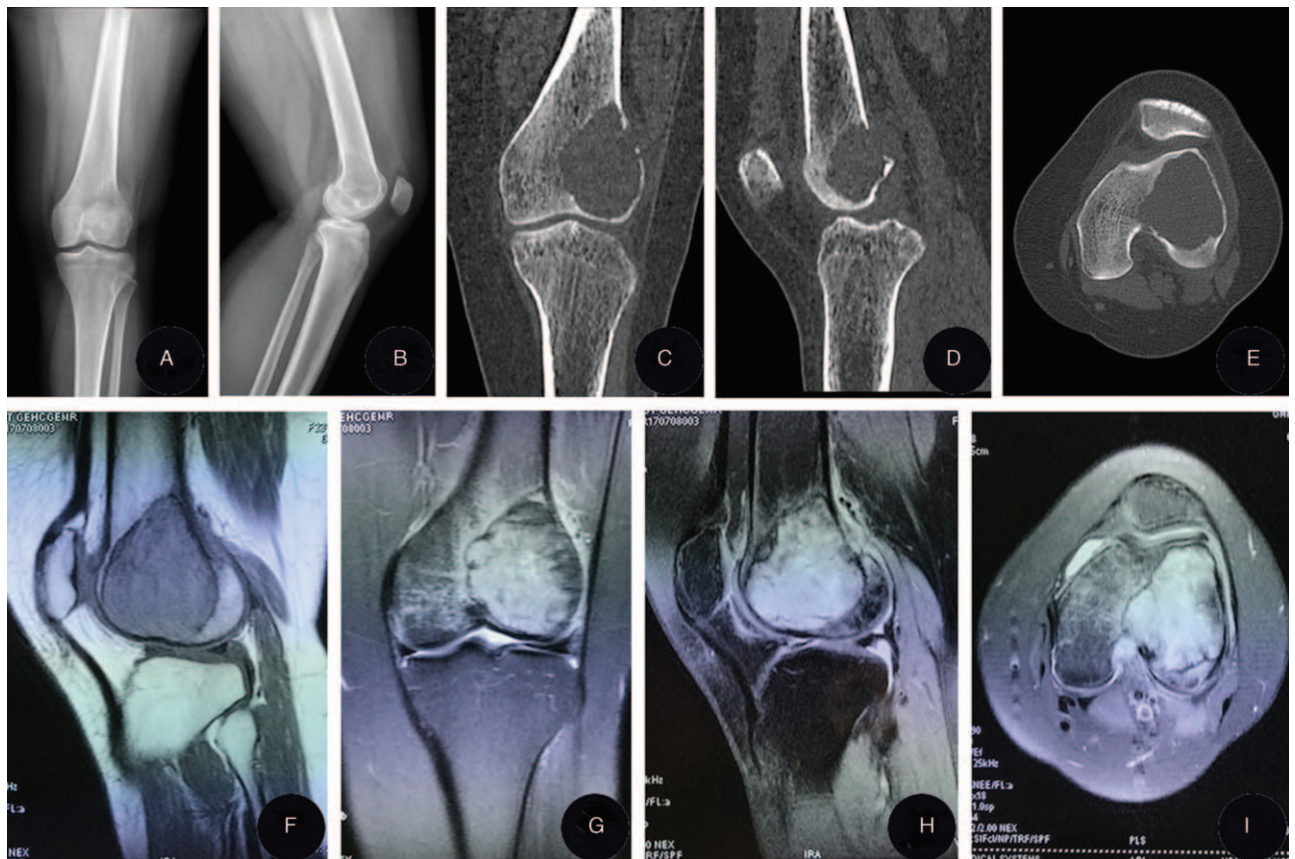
(A, B) Preoperative X-ray of a case of giant cell of bone of the distal femur showing cortical thinning and resorption of the subchondral bone. (C–E) Preoperative computed tomography scan showing a lytic appearance and epiphyseal lesion without sclerotic margin. (F) Preoperative T1-weighted magnetic resonance imaging (MRI) showing the lesion at the distal femur with relatively low-intensity change. (G–I) Preoperative T2-weighted MRI showing a heterogeneous mixed high-intensity change with surrounding soft-tissue edema.
